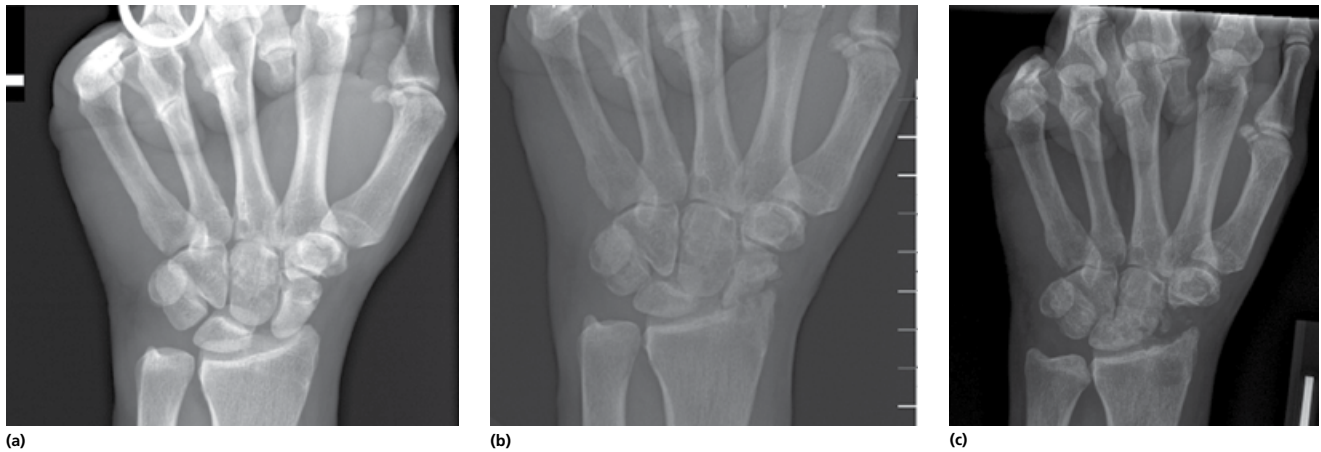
(a) Radiograph showing scapholunate widening. The patient had wrist pain, popping and decreased range of motion but chose to treat non-operatively. (b) Postero-anterior wrist X-ray 4 years later of the same patient. He now has severe pain even with rest. There are advanced degenerative changes at the radioscaphoid joint and significant degeneration at the capitulunate joint. The radiolunate articulation is spared. (c) A scaphoid excision and four-corner fusion was performed. The patient was able to return to work as a construction worker.
